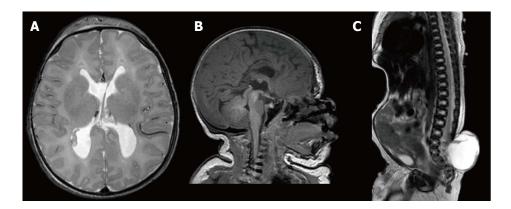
Pre-operative magnetic resonance imaging imaging of the patient to evaluate and screen for anatomical abnormalities. A: Axial T2 MRI of the head at birth demonstrating no signs of hydrocephalus; B: Sagittal T1 MRI of the head and neck at birth with evidence of a tight cervicomedullary junction, a small posterior fossa, and hypoplastic corpus callosum and cerebellar vermis; C: Sagittal T2 MRI of the spine at birth demonstrating a large 7 cm × 7 cm sacral myelomeningocele with evidence of tethering. MRI: Magnetic resonance imaging.
